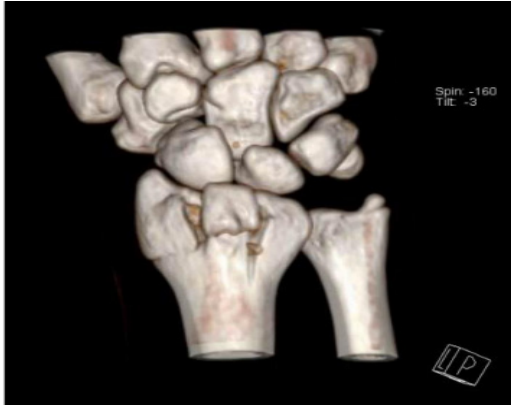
3D Reconstructed CT wrist showing the fractures.
